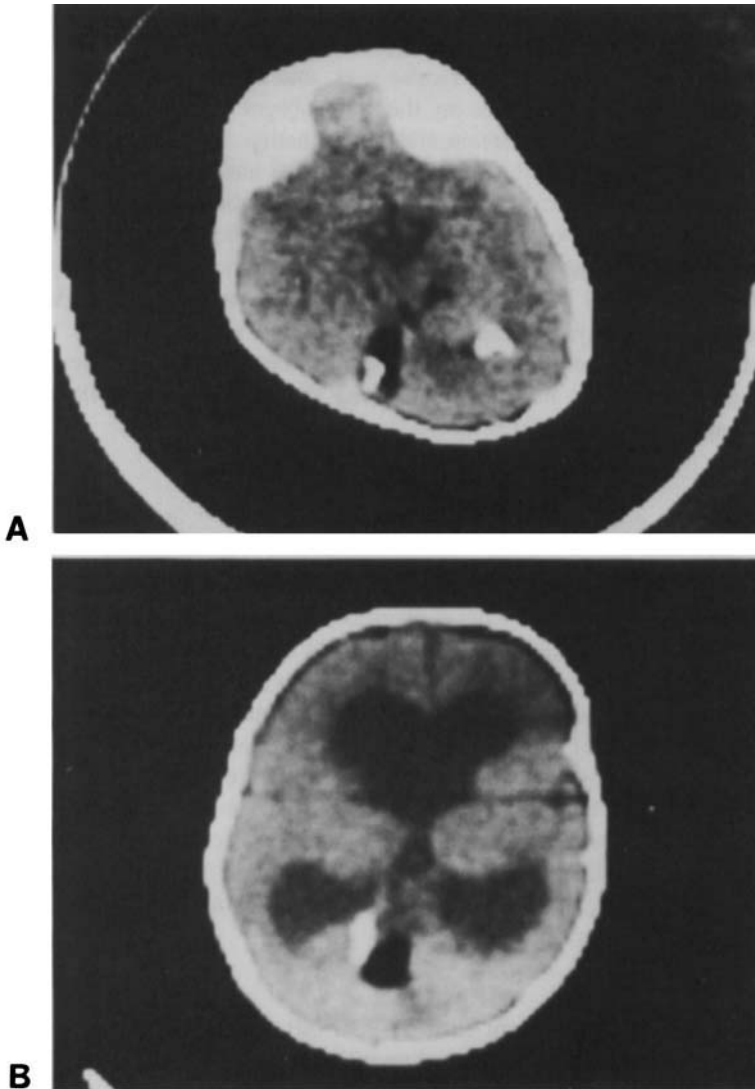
CT Scans of patient 1(A) and patient 2(B) showing occipital masses with densities characteristic of fat and bone.
